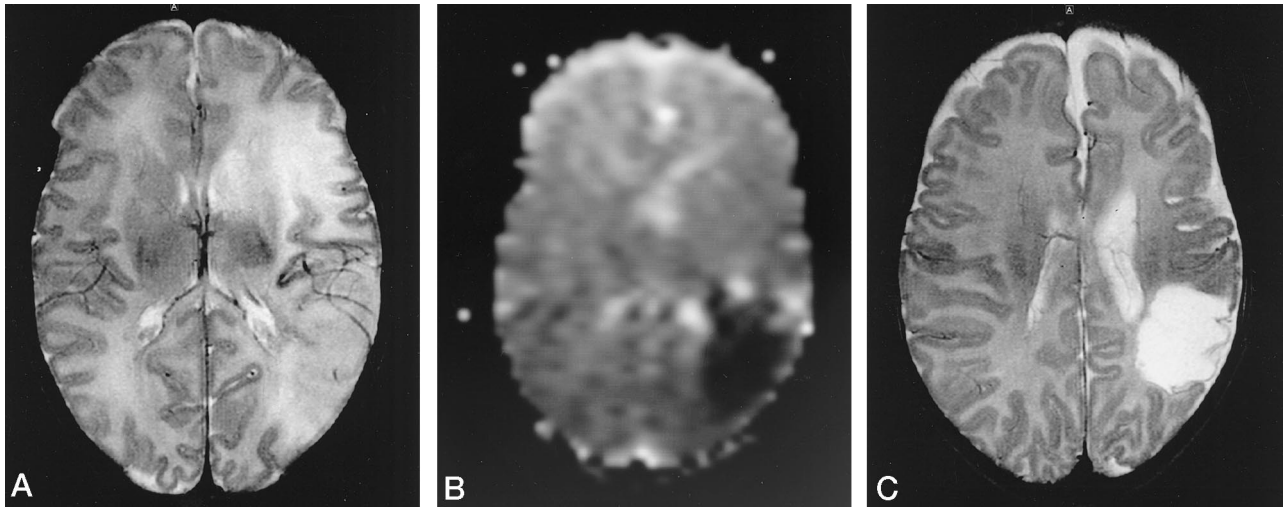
A and B, Axial T2-weighted image (A) and corresponding ADC (B) of a 6-day-old neonate obtained 3 days after onset of stroke symptoms. A shows the hyperintense ischemic lesion in the territory of the left MCA with partial effacement of the temporooccipital cortex. B shows low ADC values (dark area) in the temporal region, although the T2 hyperintensity appears homogeneous throughout the lesion.
